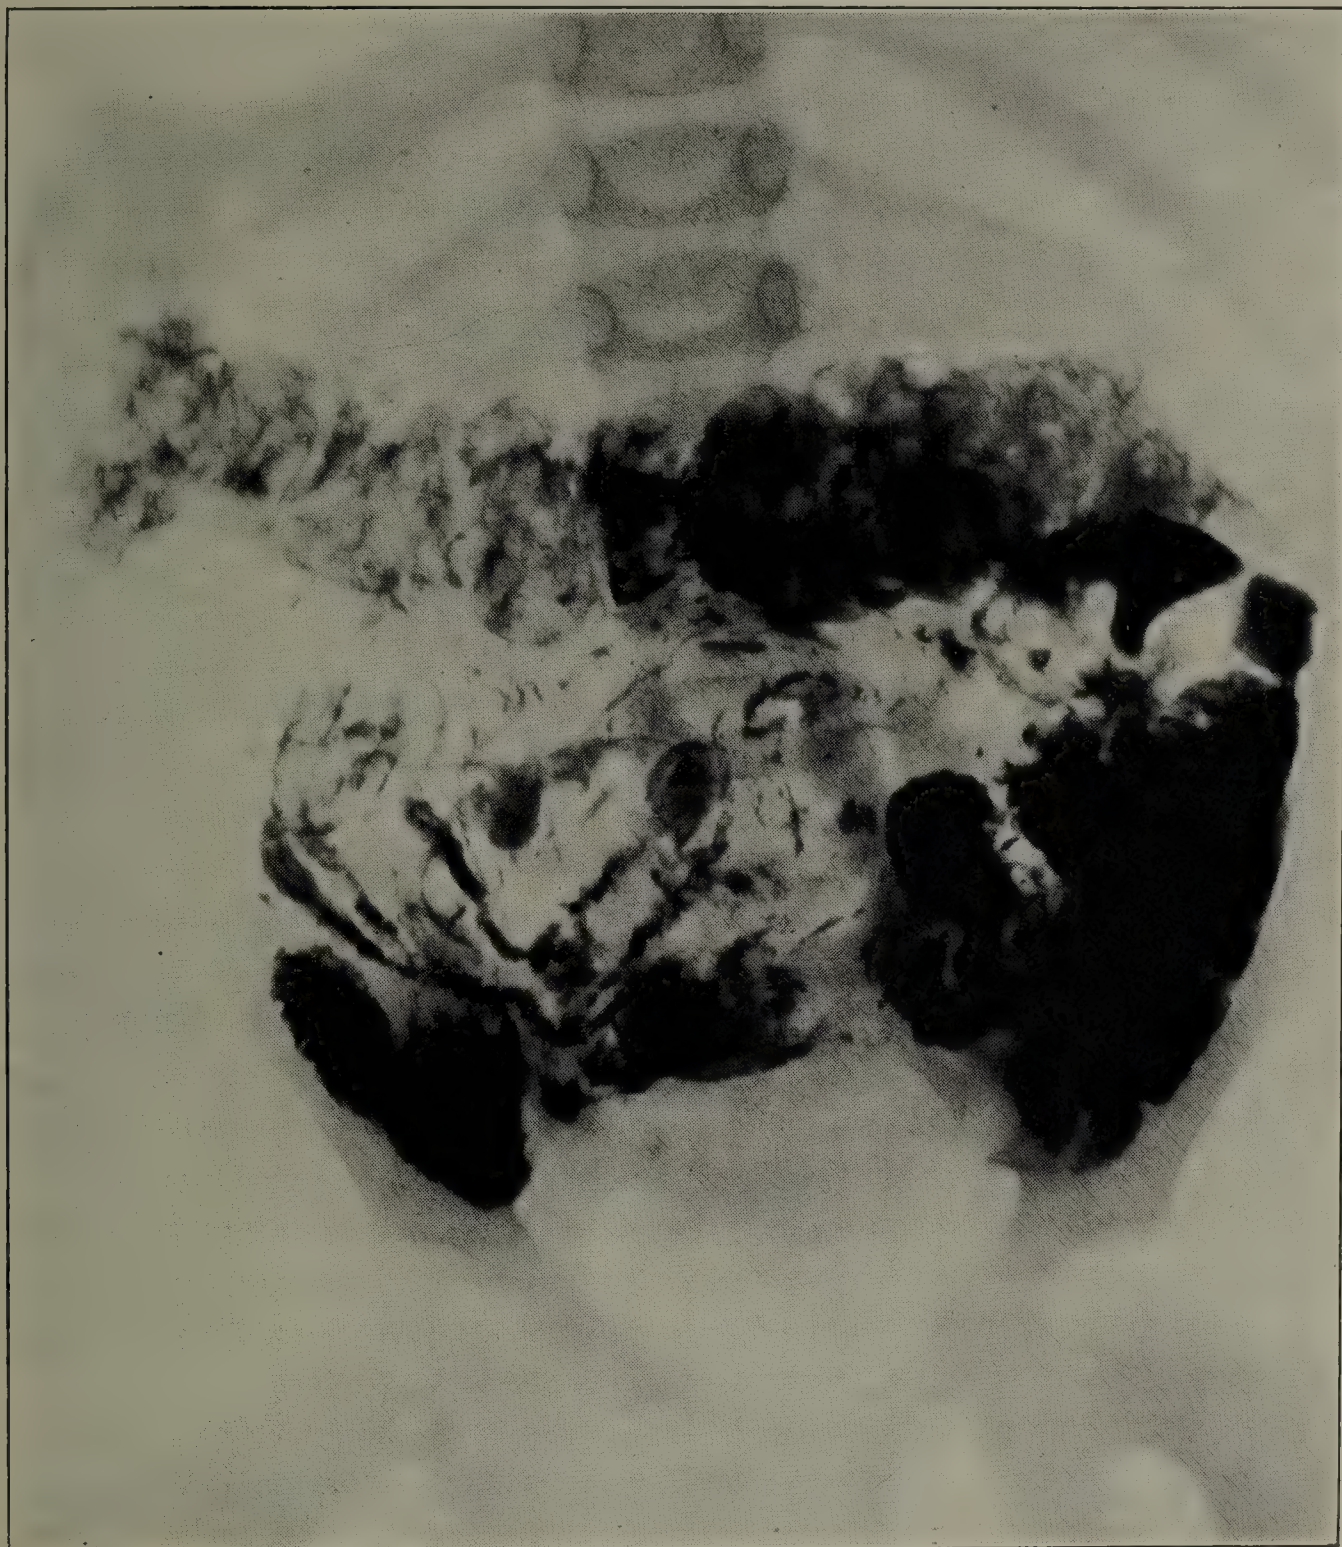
ROENTGENOGRAM IN ASCARIASIS, FOLLOWING BARIUM MEAL.
